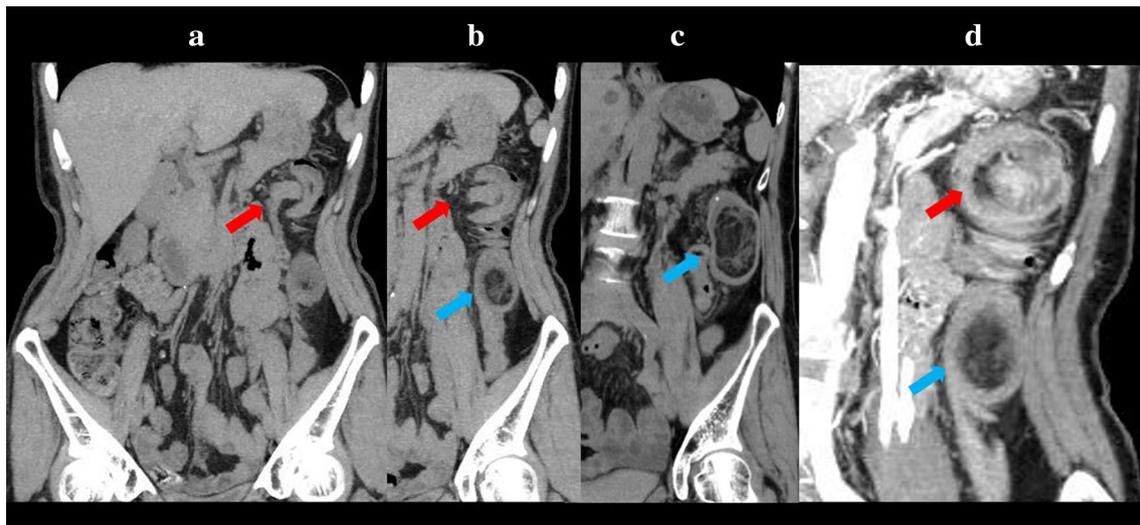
Coronal views of an abdominal computed tomography (CT) scan. a–c Plain images, showing a colo-colonic intussusception (red arrows) low-density mass as the lead point (blue arrows). The base
